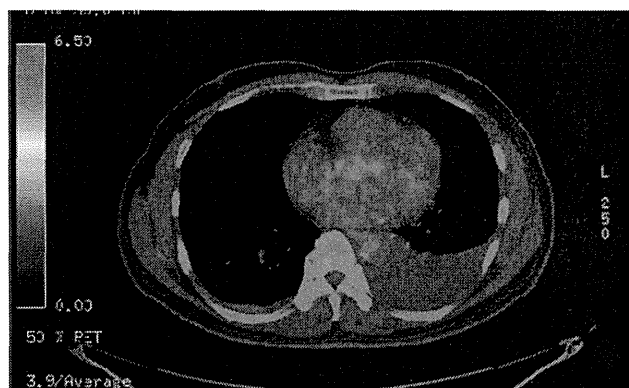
PET–CT revealed left pleural effusion and mild accumulation of fluorodeoxyglucose along the right dorsal pleura
